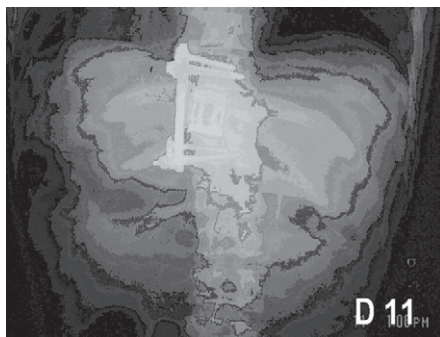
post operative X-Rays showing cage placement and plating (TSRH)
